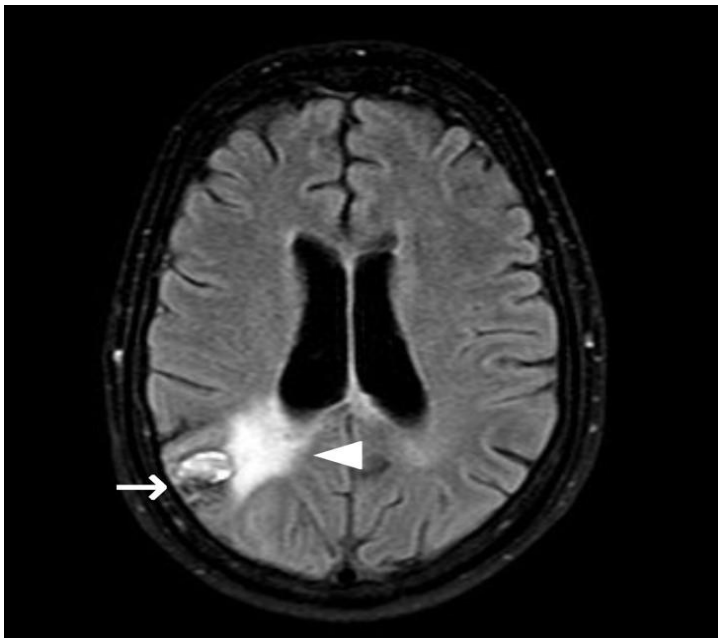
MRI images in axial FLAIR sequence showing vasogenic edema (arrowhead) adjacent to the cavernoma (white arrow).
